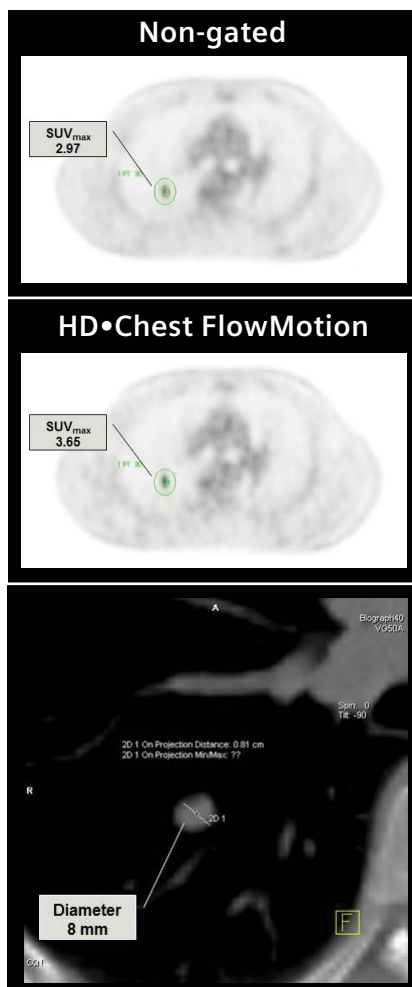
CT shows a solitary lung nodule with a diameter of 8 mm. HD•Chest shows higher SUV_{max} of 3.65 of the lung nodule compared to SUV_{max} of 2.97 obtained from non-gated PET acquisition of the lung.
